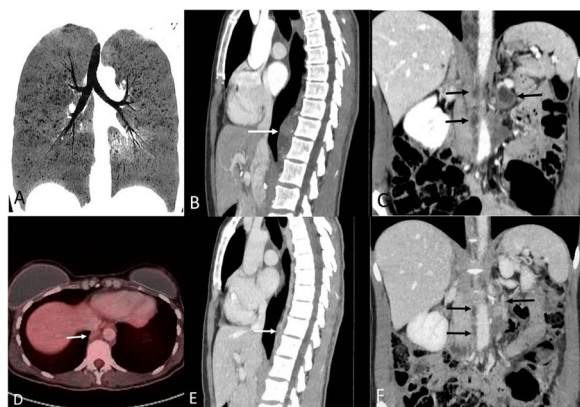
(A) Coronal minimum intensity projection (minIP) thoracic CT image (lung window) shows multiple small cystic lesions in both lungs. (B) Sagittal thoracic CT image (mediastinal window) shows a low-attenuation prevertebral mass (arrow). (C) Coronal abdominal CT image shows low-attenuation lesions in the retroperitoneum (arrows). (D) Axial fused lower thoracic PET/CT image shows minimal FDG uptake by the posterior mediastinal lesion. (E) and (F) Sagittal thoracic (E) and coronal abdominal (F) CT images show an almost complete resolution of the masses (arrows) 3 months after sirolimus therapy was started.
